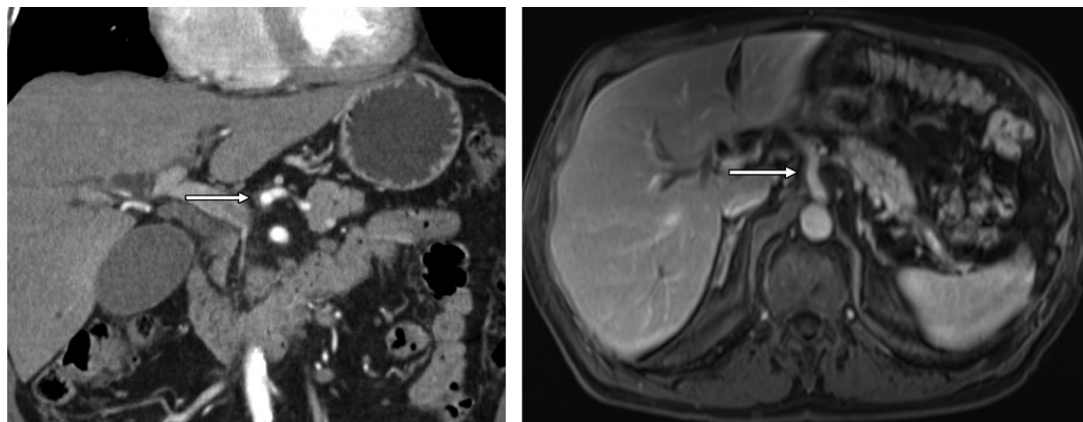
Missed vascular involvement in a 55-year-old woman with pancreatic cancer. Axial CT (a) and MR (b) images show soft-tissue encasement of the celiac artery (arrow), which was missed at preoperative staging. The patient proceeded to pancreatectomy; within 3 months of surgery, she was found to have progression. Had this finding been identified preoperatively, the case would have been considered unresectable and the patient would have undergone only chemoradiation therapy. Unnecessary surgery in this case negatively impacted the patient's quality of life. It is possible that double reading could have identified this finding before surgery and spared the patient unnecessary surgery.
